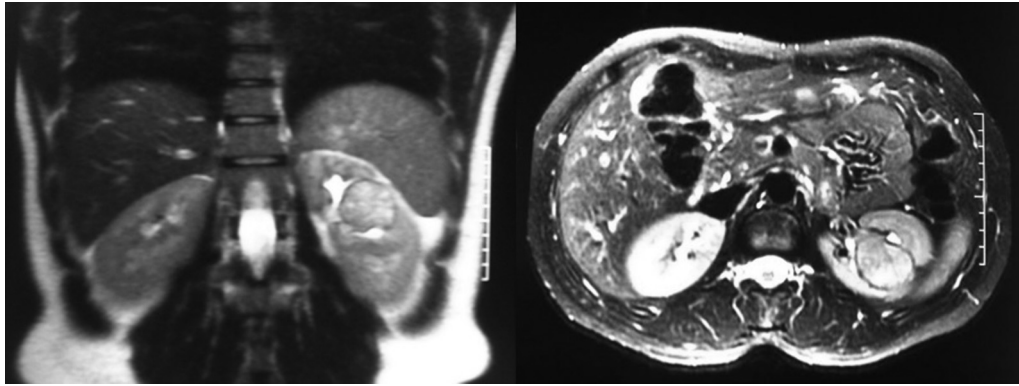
MRI showing expansive formation, well defined contours, heterogeneous, endophytic, between the middle and upper third, intimate contact with the renal sinus, with no apparent vascular invasion measuring approximately 3.4 cm.
